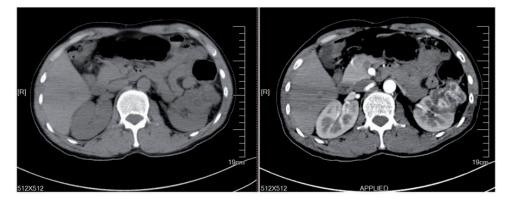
Computed tomography image showing renal cell carcinoma in the left kidney.
